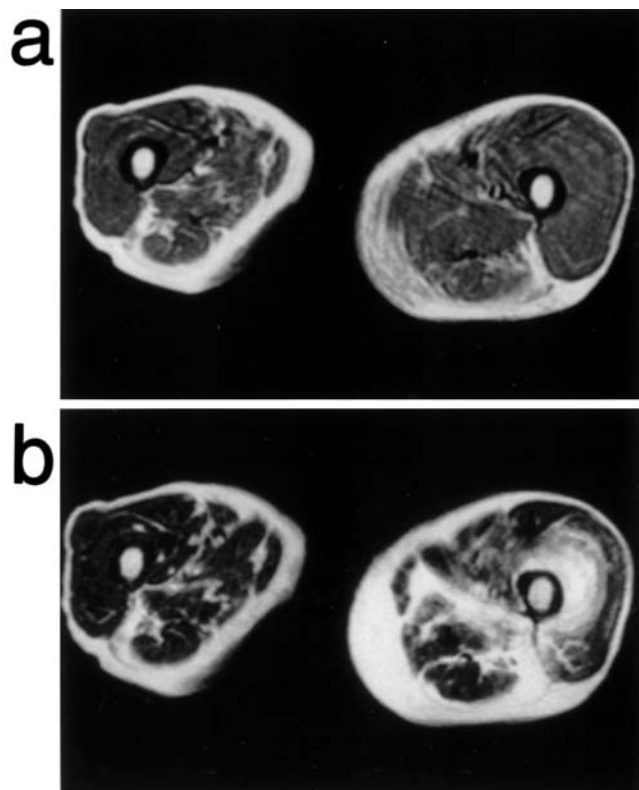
Magnetic resonance imaging findings in the left thigh. a Normal appearance in a T1-weighted image. b Increased signal intensity in the vastus intermedius and adductor magnus muscles in a T2-weighted image
